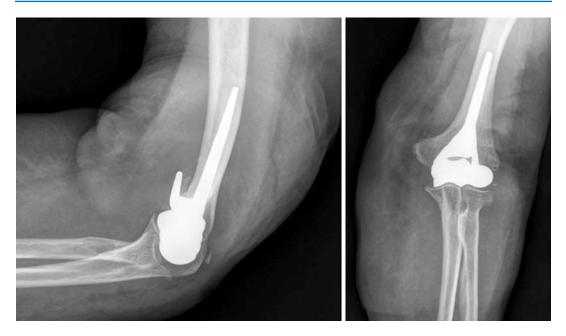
One-month follow-up X-rays (lateral and anteroposterior views) of a hemiarthroplasty with a convertible implant in a distal humeral fracture case of the left elbow in an 80-year-old woman
